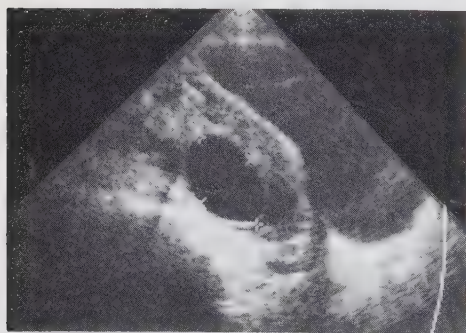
A typical ultrasound representation of an unruptured follicle from an anovulatory cycle in a woman who had used NORPLANT-2 for more than three years. The picture is taken on cycle day 25. Maximum diameter is 34.9 mm.
